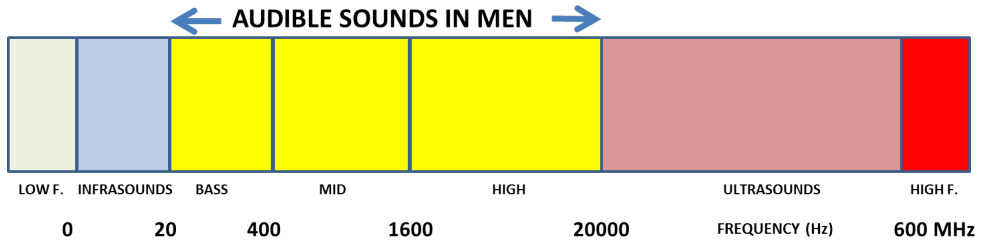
Human audition and ultrasound frequencies in Hz
